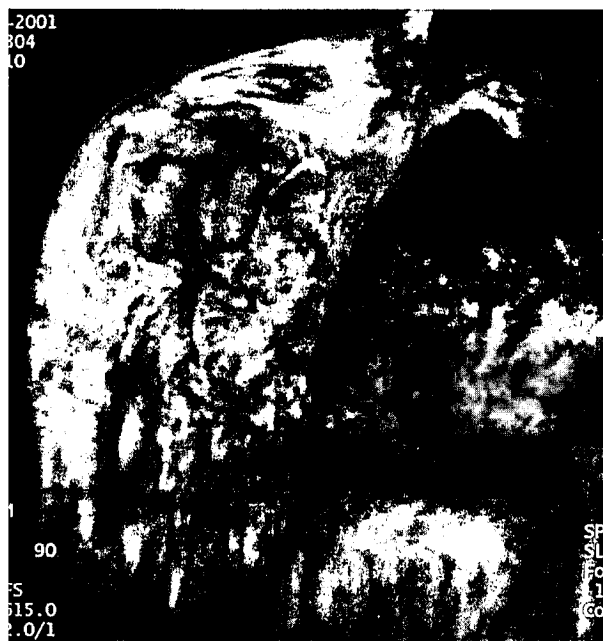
Chronic recurrent multifocal osteomyelitis of the right clavicle. Note the vast soft tissue swelling around the bone extending wide into the axillary area (spin echo T1 weighted, fat suppression MRI, after intravenous gadolinium-DTPA).
